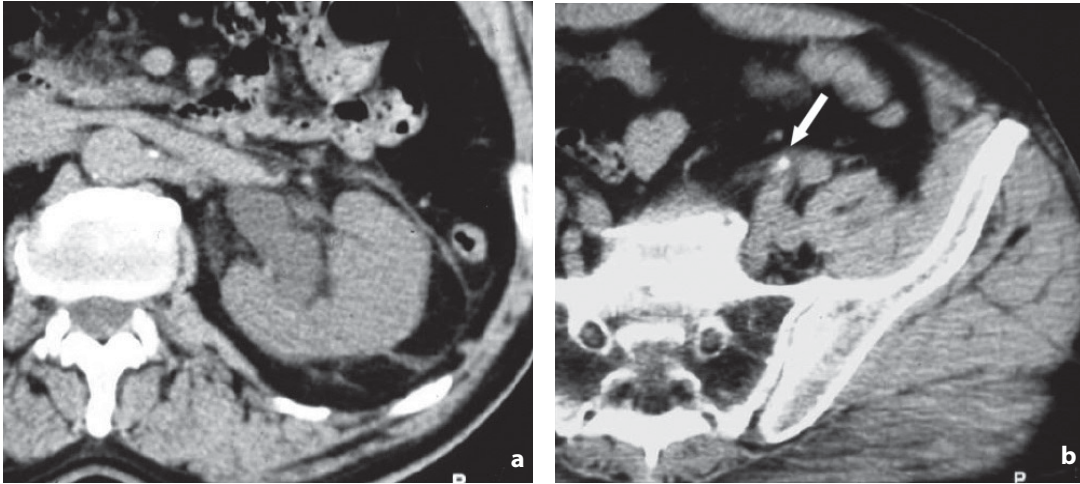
Nonenhanced CT. Ureteric stone (patient with left renal colic). Slight hydronephrosis, thickening of the renal septa and fascia with perirenal (a) and periureteric (b) stranding. Stone (*arrow*) lodged in the ureter at the crossing with the iliac vessels
